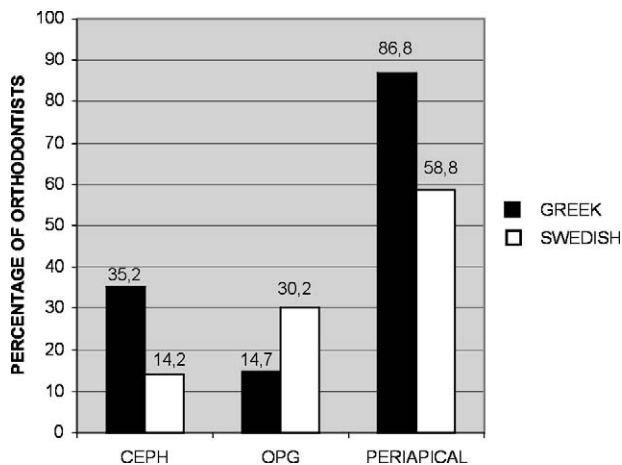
Comparison of the regular use of radiographs by Greek and Swedish practitioners for the initial diagnosis of root resorption.
